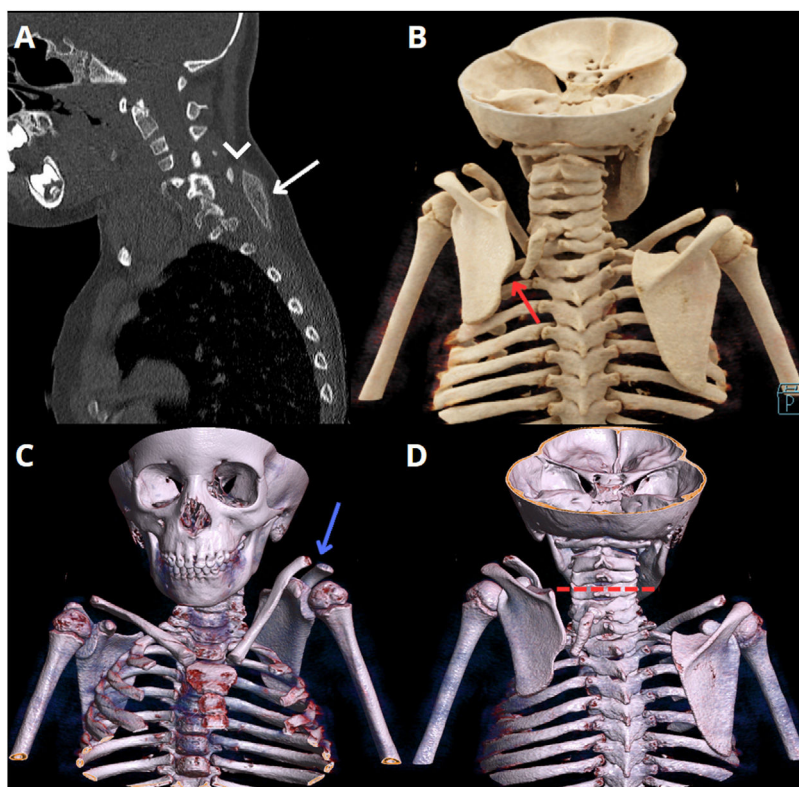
A) Simple cervicodorsal spine CT, sagittal plane in bone window, with omovertebral bone (white arrow) that at its superior border is joined to the C5 transverse process/lamina (white arrowhead). B) 3D-VRT reconstruction which shows the medial border of the scapula and lowest edge of the omovertebral bone, and the absence of osseous bridges between the two (red arrow). C) 3D-VRT reconstruction in anterior plane, with a marked elevation of the left scapula and clavicle (blue arrow), attributable to Sprengel's deformity. D) 3D-VRT in posterior plane, which shows that the superomedial border of the scapula is at the level of C4 (dotted red line) (Rigault's classification Grade III).
